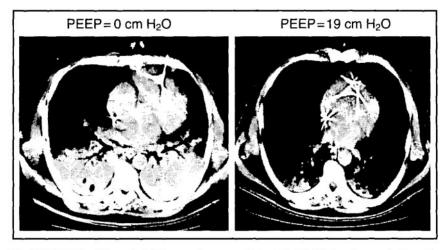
Thoracic CT images from a patient with ARDS showing resolution of atelectasis (recruitment) in response to PEEP. Images from Barbas CSV. Lung recruitment maneuvers in acute respiratory distress syndrome and facilitating resolution. Crit Care Med 2003;31(suppl):S265–S271.
